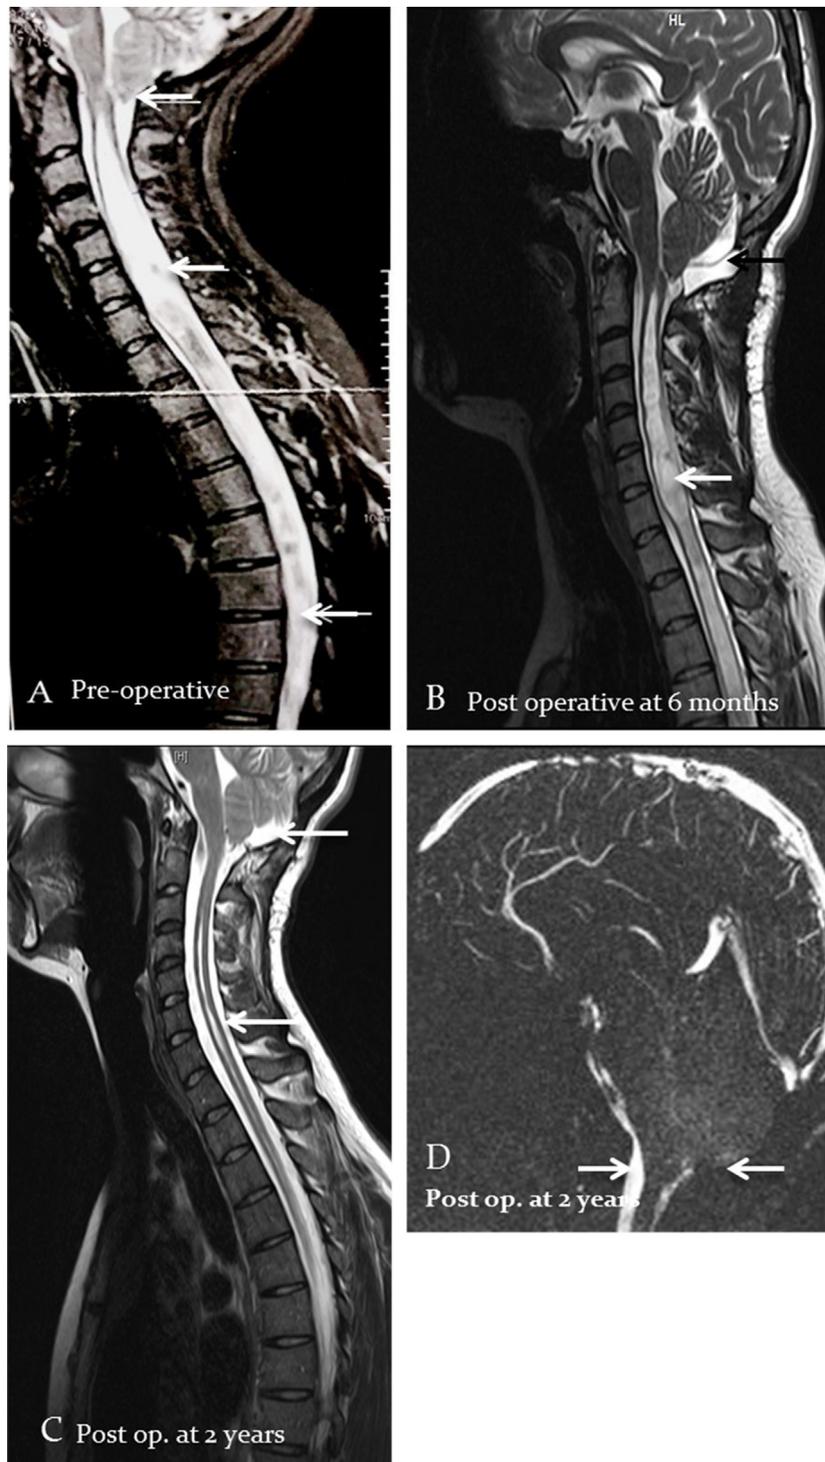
A. Preoperative MRI in the T2 sagittal sequence showing a CM-I (white arrow) associated with pan medullary syringomyelia (white arrows). B. Postoperative MRI at 6 months after suboccipital decompression, C1 laminectomy and duraplasty in T2 sagittal sequence showing adhesion of duraplasty at the posterior cerebral fossa (black arrow) and a decrease in size of the syrinx cavity (white arrow). C. Postoperative 2 years follow-up. MRI in T2-imaging demonstrating an artificial cisterna magna, rounded shape of tonsil and reduction in syrinx size (white arrows). D. On the flow MRI sequence we note the presence of CSF flow around the foramen magnum (white arrows).
